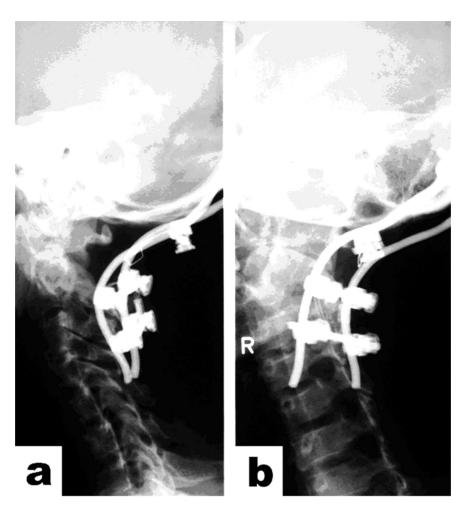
Postoperative lateral (a) and oblique (b) plain X-ray views one week after occipitocervical fixation.
